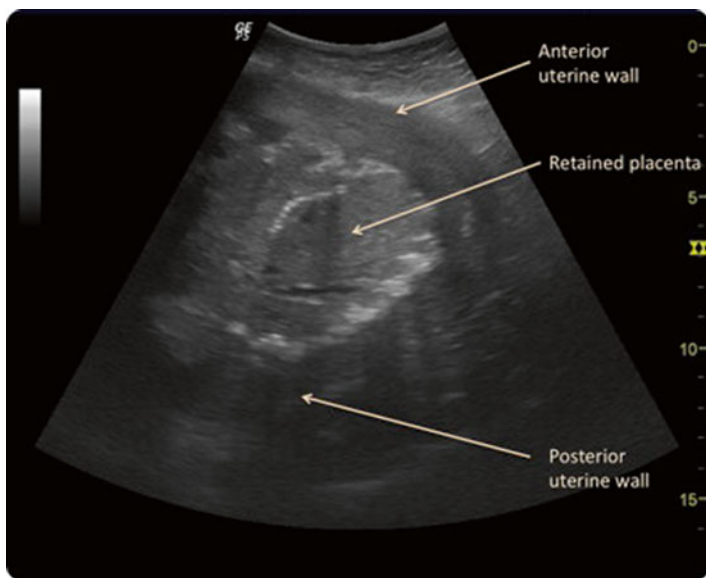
Retained placenta. Ultrasound image of retained placenta in situ (Reprinted from Rosenstein and Vargas [27] with permission from Elsevier)
